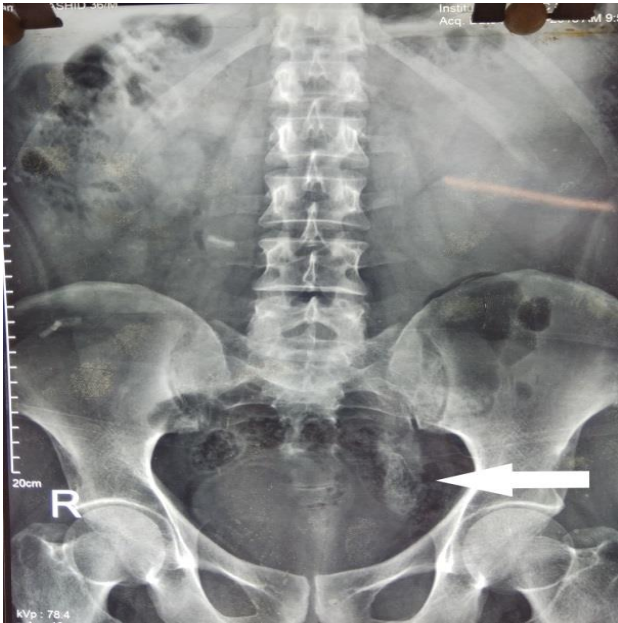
A plain radiograph of kidney ureter bladder showing left lower ureteric calculus.
